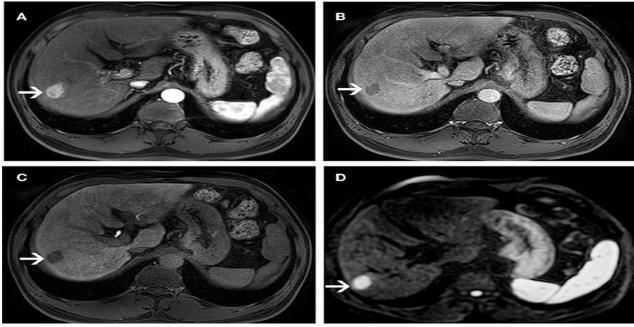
MRI of Liver Cirrhosis
